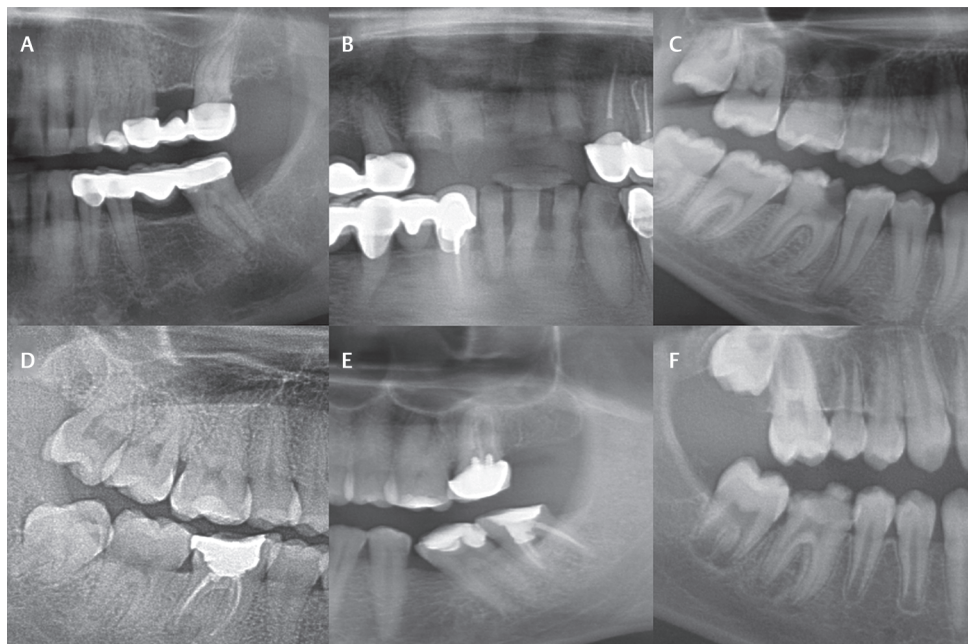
Radiographies of the cases in the survey. (A) Radiography of case 1. (B) Radiography of case 2. (C) Radiography of case 3. (D) Radiography of cases 4 and 5. (E) Radiography of case 6. (F) Radiography of case 7.
